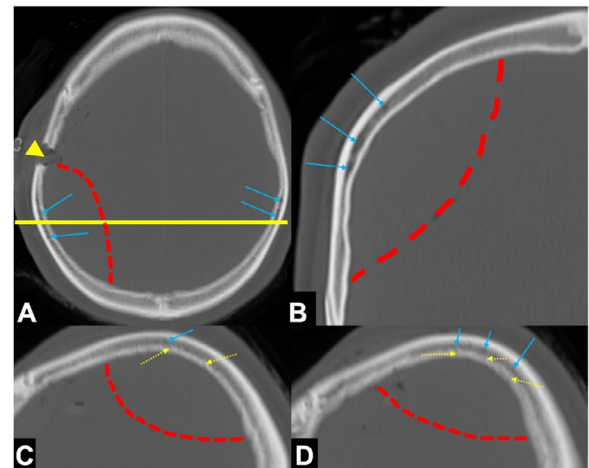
Axial (A), coronal (B), and contiguous sagittal (C and D) computed tomography scans at the level of the center of the epidural hemorrhage (A, solid line), performed immediately after burr-hole irrigation, showing fine connecting channels (C and D, dashed arrows) between the diploic spaces (a–d, arrows) and extracranial sites. Arrowhead: burr-hole; Dashed line: inner (A and B) and lower (C and D) margins of acute epidural hemorrhage.
